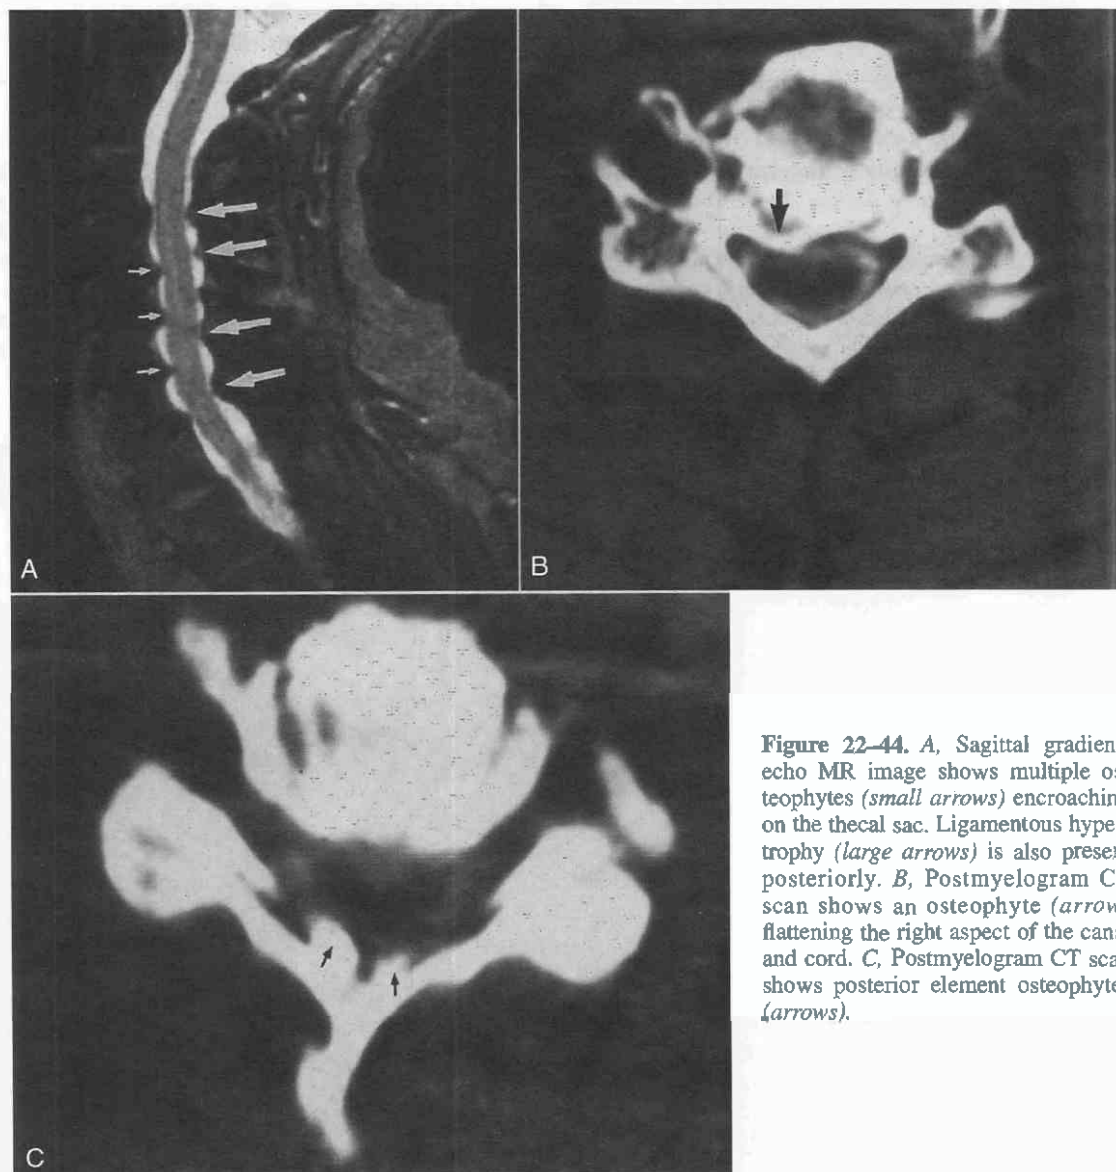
A, Sagittal gradient-echo MR image shows multiple osteophytes (*small arrows*) encroaching on the thecal sac. Ligamentous hypertrophy (*large arrows*) is also present posteriorly. B, Postmyelogram CT scan shows an osteophyte (*arrow*) flattening the right aspect of the canal and cord. C, Postmyelogram CT scan shows posterior element osteophytes (*arrows*).
